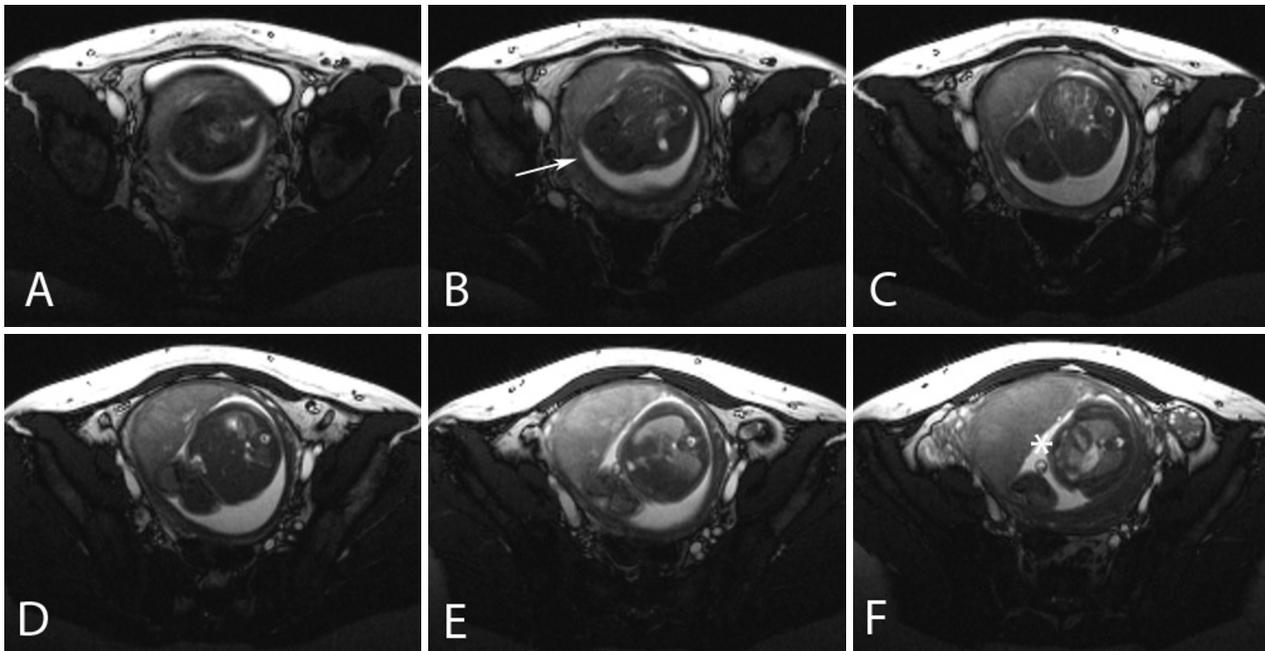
24-week-old fetal female with sirenomelia. Axial T2 MR images demonstrate absent urinary bladder (A), fused lower extremities (B-F), absent kidneys (B, C), cardiomegaly (F), oligohydramnios, and two-vessel umbilical cord (E, F [star]).
